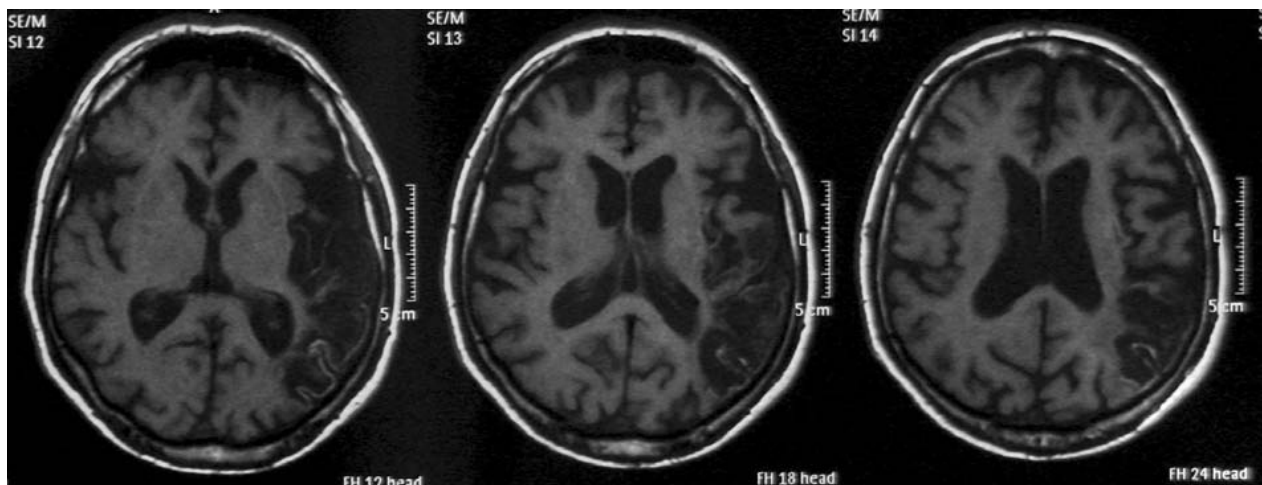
Samples of MRI.
